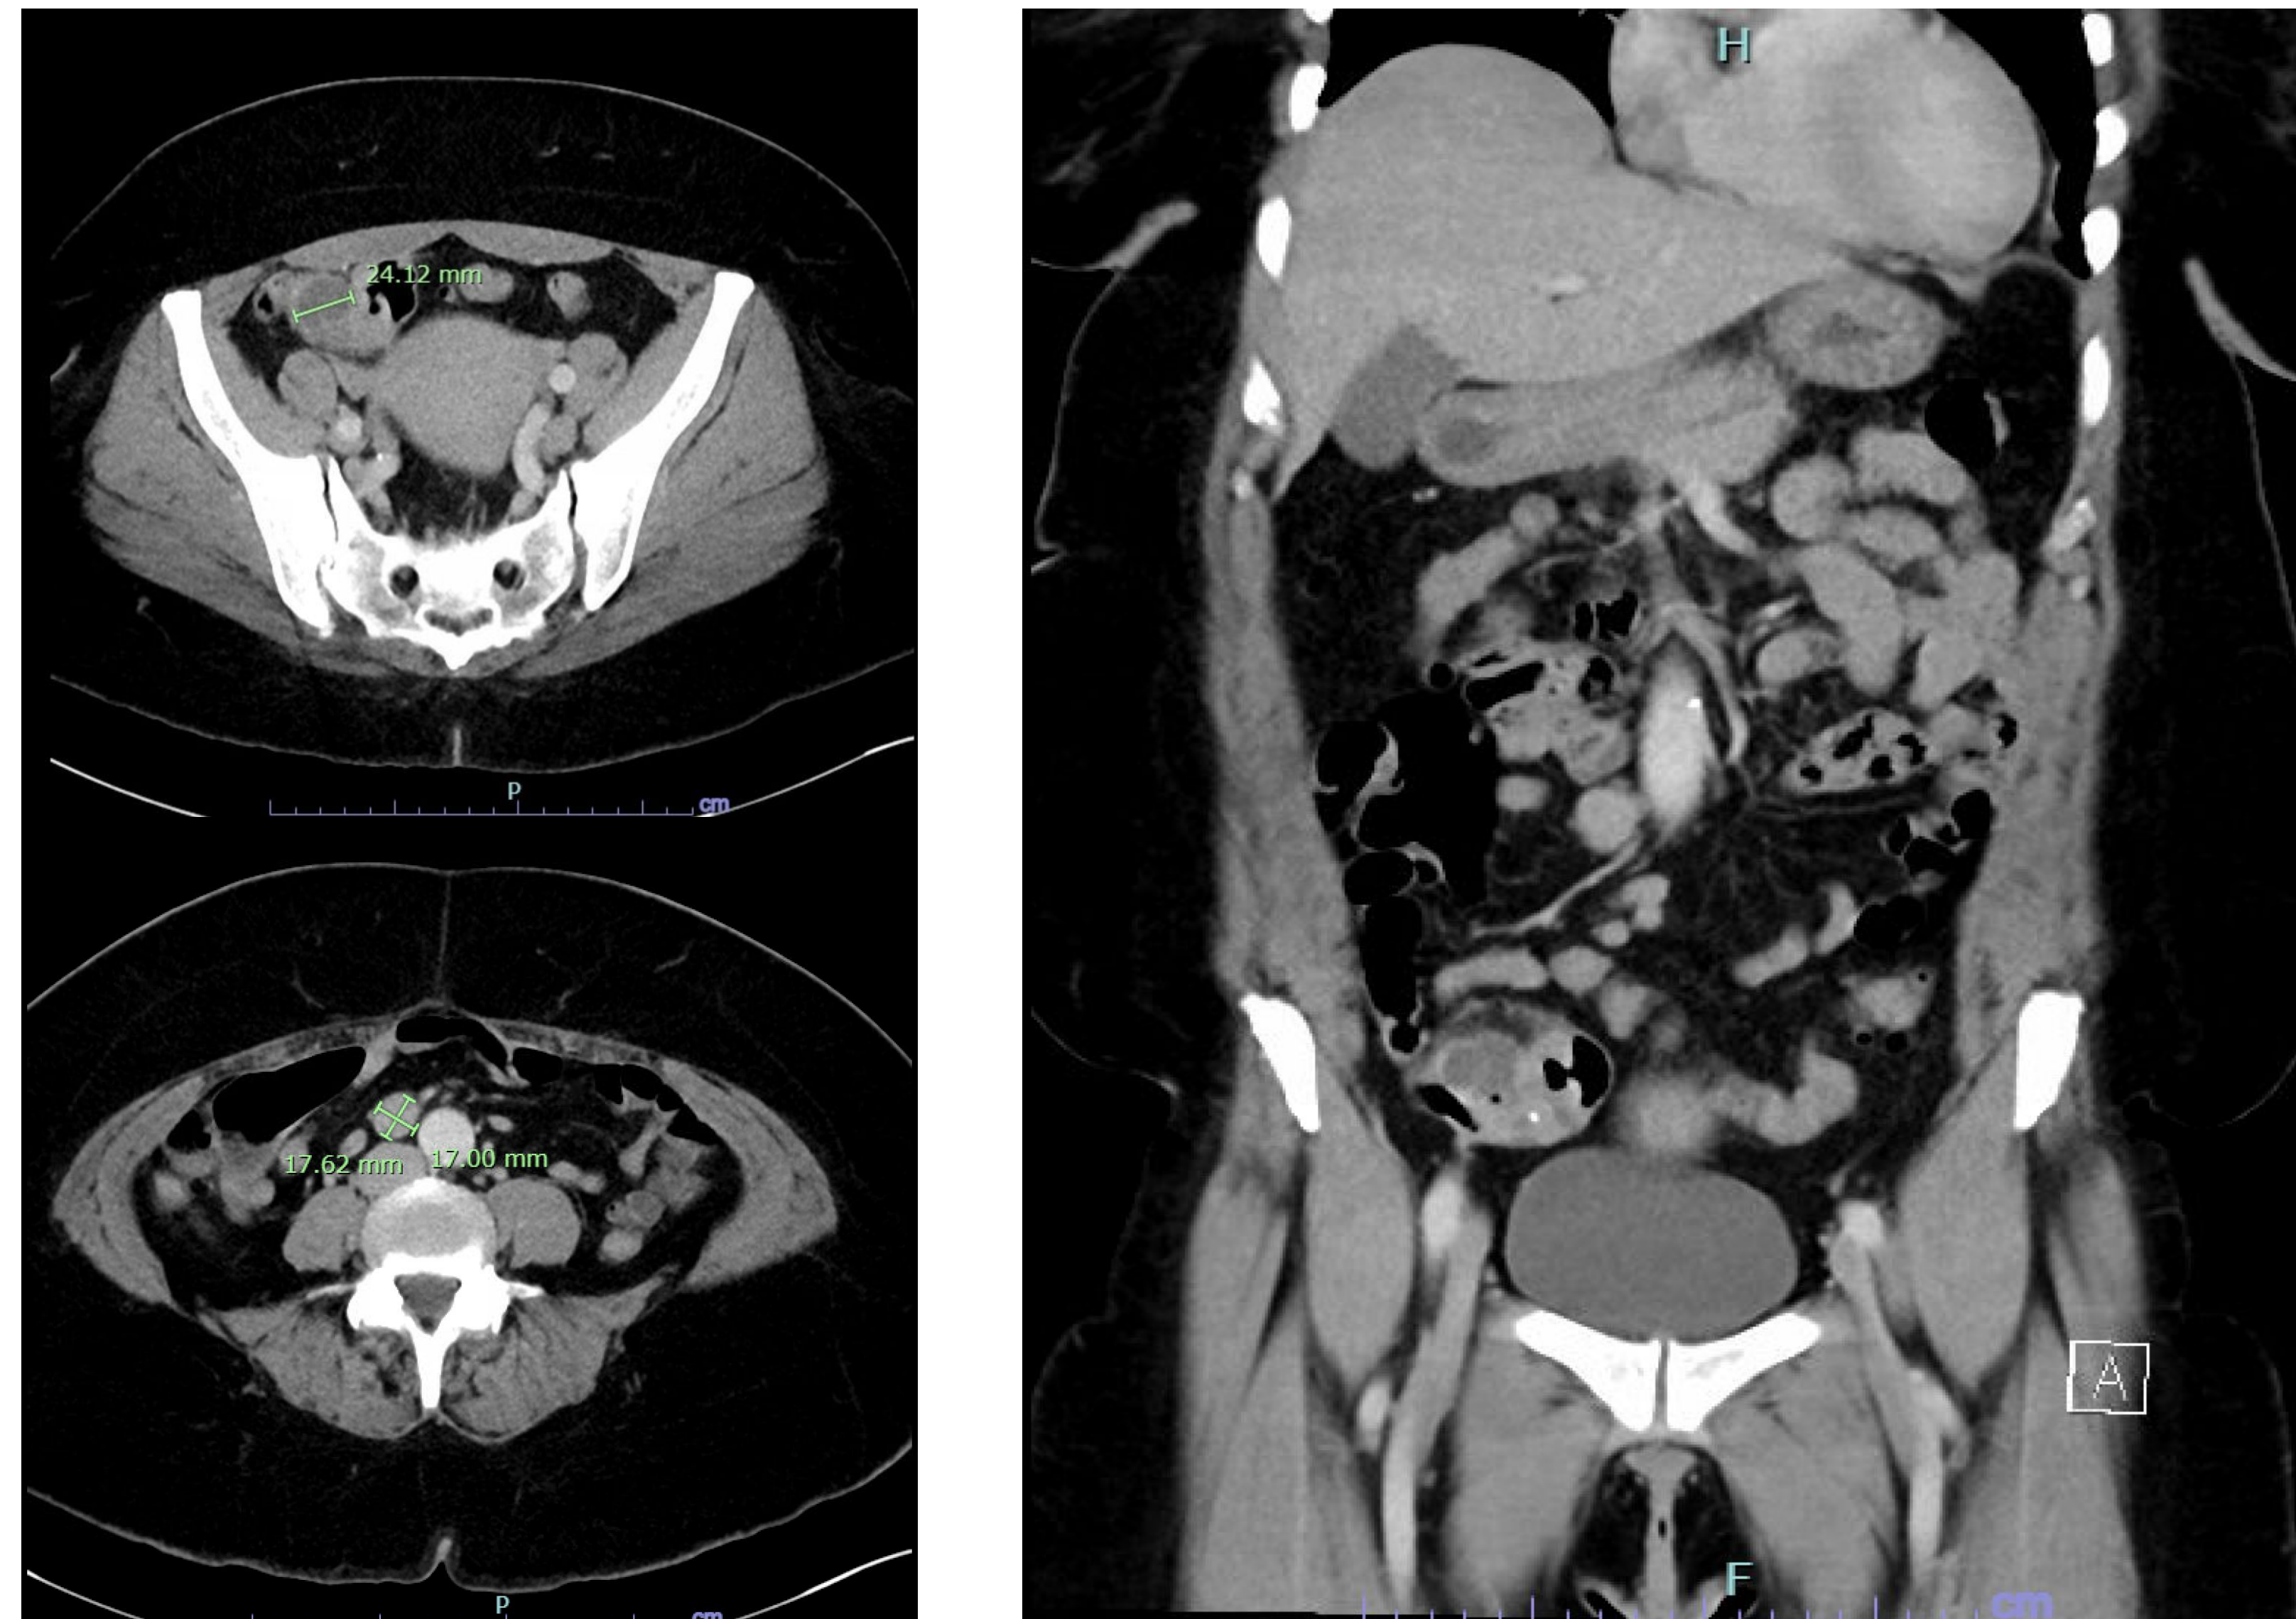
CT images of severe irregular thickening in a loop of small bowel in RLQ and enlarged 1.7x1.8cm enlarged mesenteric lymph node
